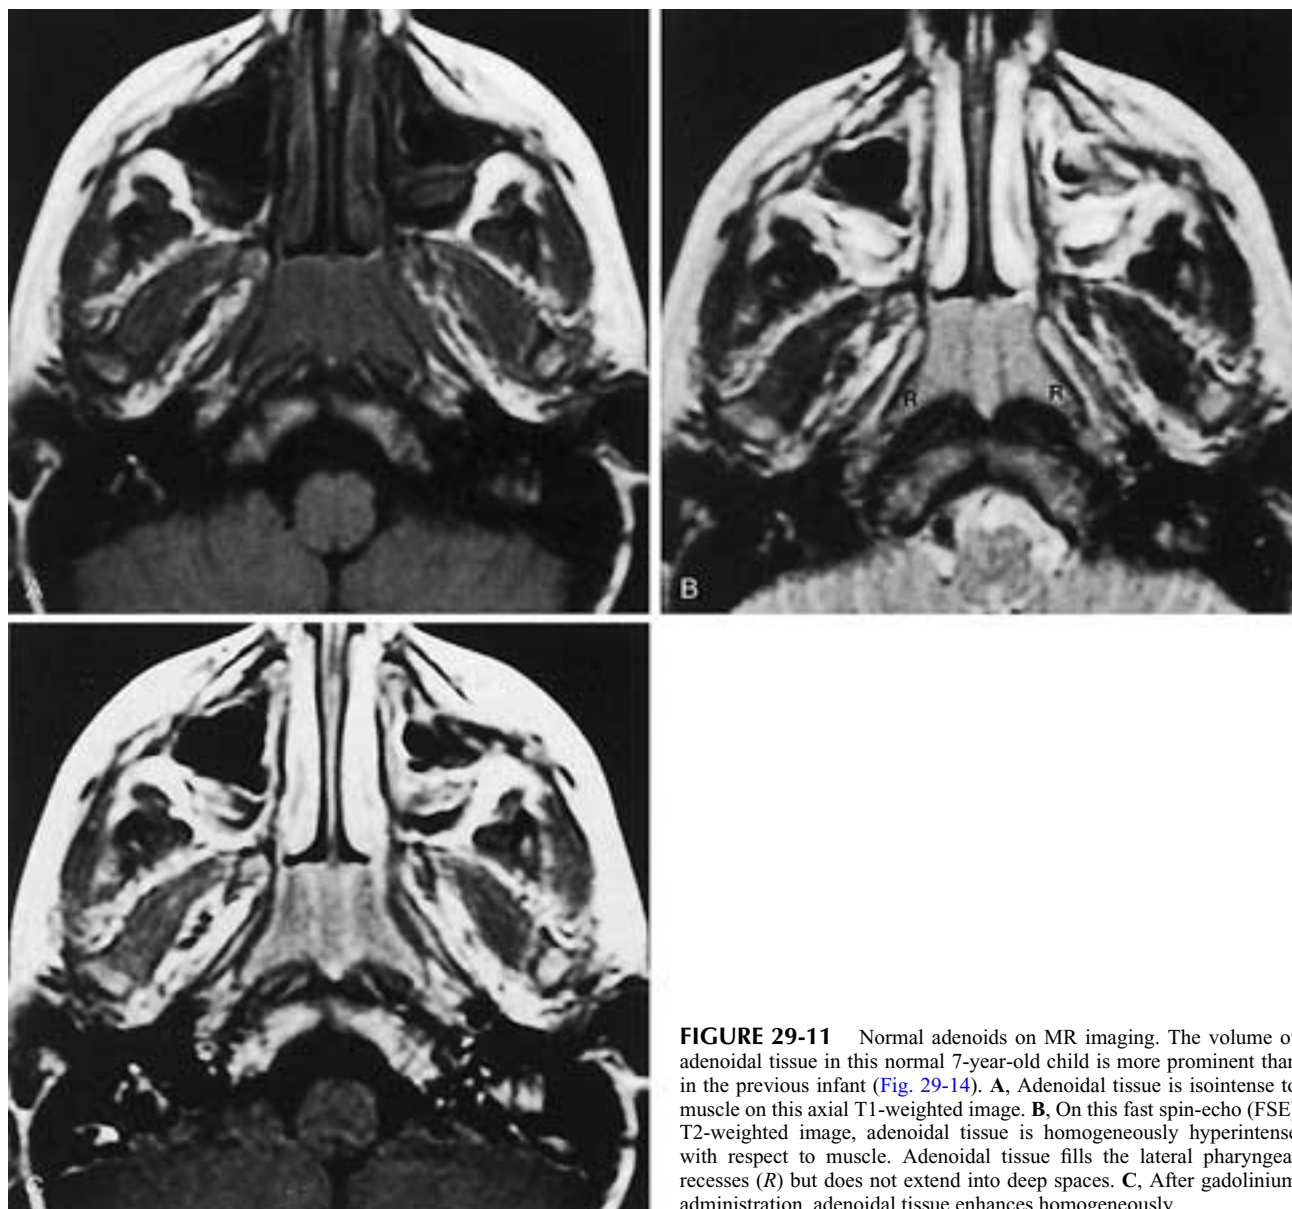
Normal adenoids on MR imaging. The volume of adenoidal tissue in this normal 7-year-old child is more prominent than in the previous infant (Fig. 29-14). A, Adenoidal tissue is isointense to muscle on this axial T1-weighted image. B, On this fast spin-echo (FSE) T2-weighted image, adenoidal tissue is homogeneously hyperintense with respect to muscle. Adenoidal tissue fills the lateral pharyngeal recesses (*R*) but does not extend into deep spaces. C, After gadolinium administration, adenoidal tissue enhances homogeneously.
